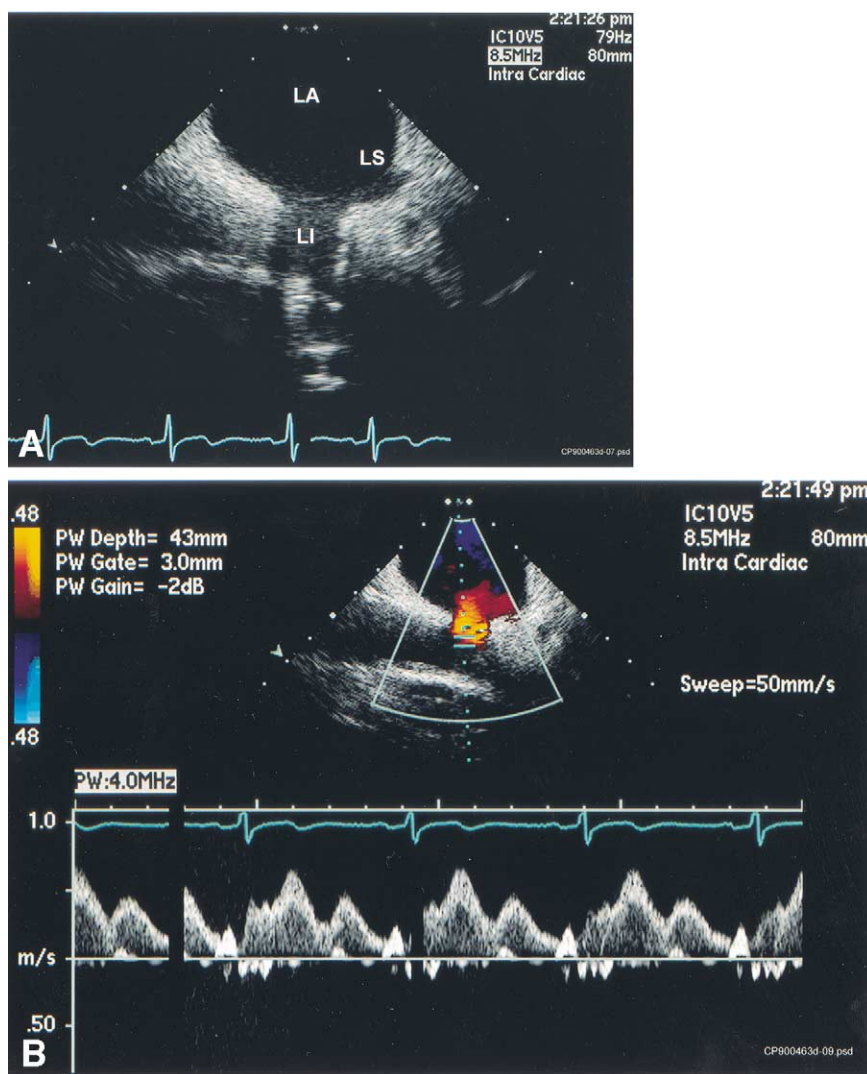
Left inferior (LI) and superior (LS) pulmonary veins entering into the posterior left atrium (LA). (A) The inferior vein entering from below and immediately to the left of the superior vein. (B) A pulsed wave Doppler tracing obtained from the inferior vessel.
